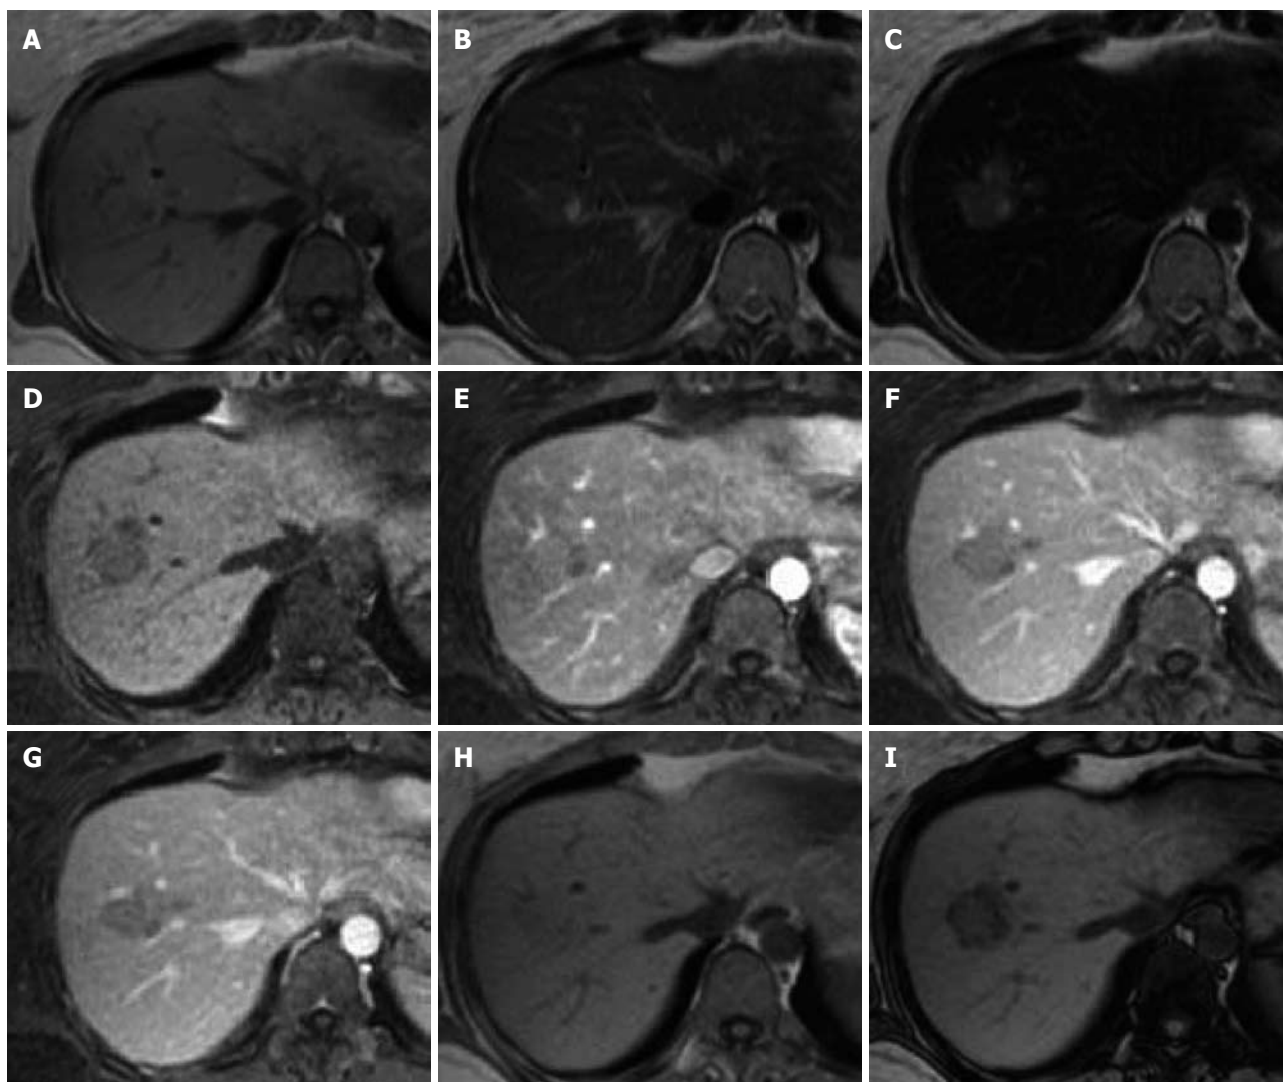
Magnetic resonance imaging (MRI). A: T1; B: T2; C: T2-SPIO; D: Plain; E: Arterial phase; F: Portal phase; G: Delayed phase; H: T1 in phase; I: T1 opposed phase.
